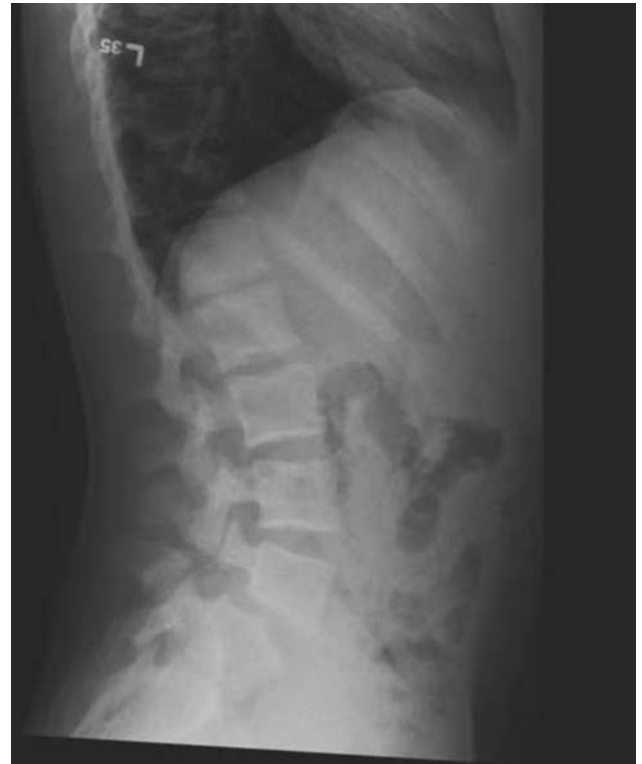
Lateral radiographs of the lumbar spine demonstrates L5 bilateral spondylolysis and grade I spondylolisthesis at the L5 to S1 level.
